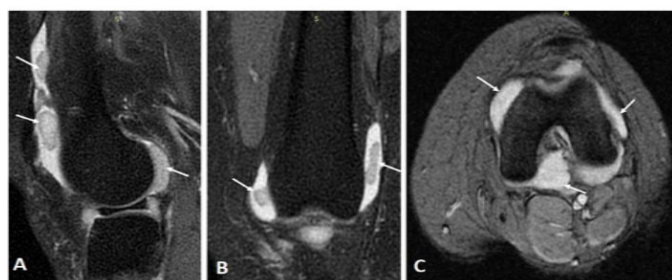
Knee MRI in proton density (PD) sagittal plane (A), coronal plane DP sequence (B), and T2* axial plane (C) showing well-limited synovial and intra-articular nodular formations in hypersignal with a rice grain appearance (arrows).
